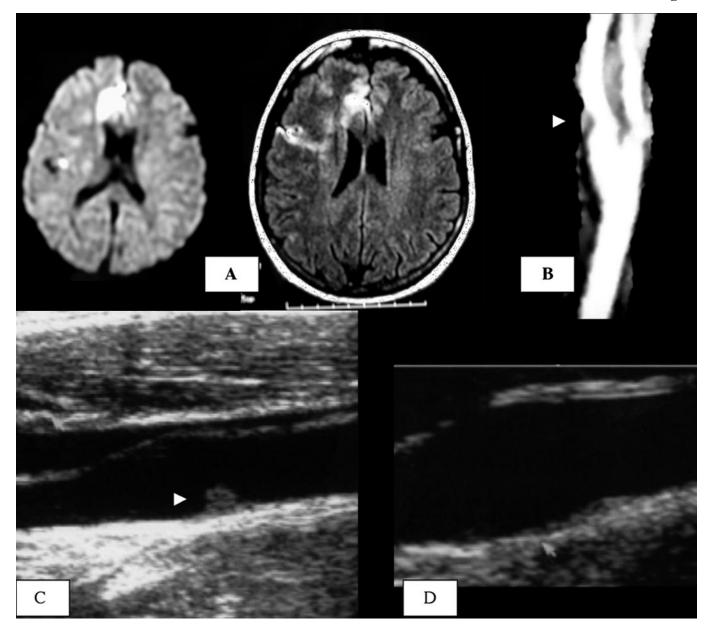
(A) Axial diffusion-weighted and fluid-attenuated inversion recovery (FLAIR) MRI: hyperintensity in right anterior and middle cerebral arteries; (B) mural thrombus of internal carotid artery (arrow) on CT scan-angiography and (C) cervical ultrasound; (D) control cervical ultrasound after 1 week.
